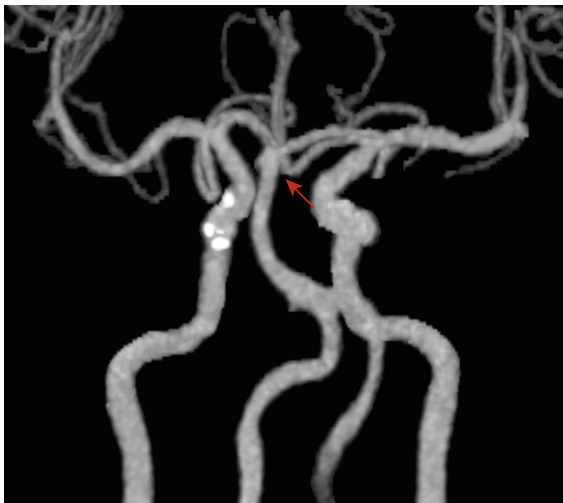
Post-treatment vascular recanalization. After 7 days of argatroban therapy, head and neck computed tomography angiography shows disappearance of the thromboembolic occlusion of the top of the basilar artery (red arrow).
